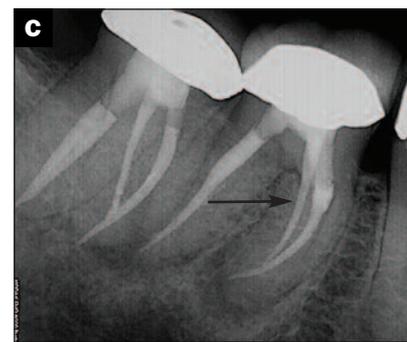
This area of conservative exploration can be seen on the postoperative radiograph.
